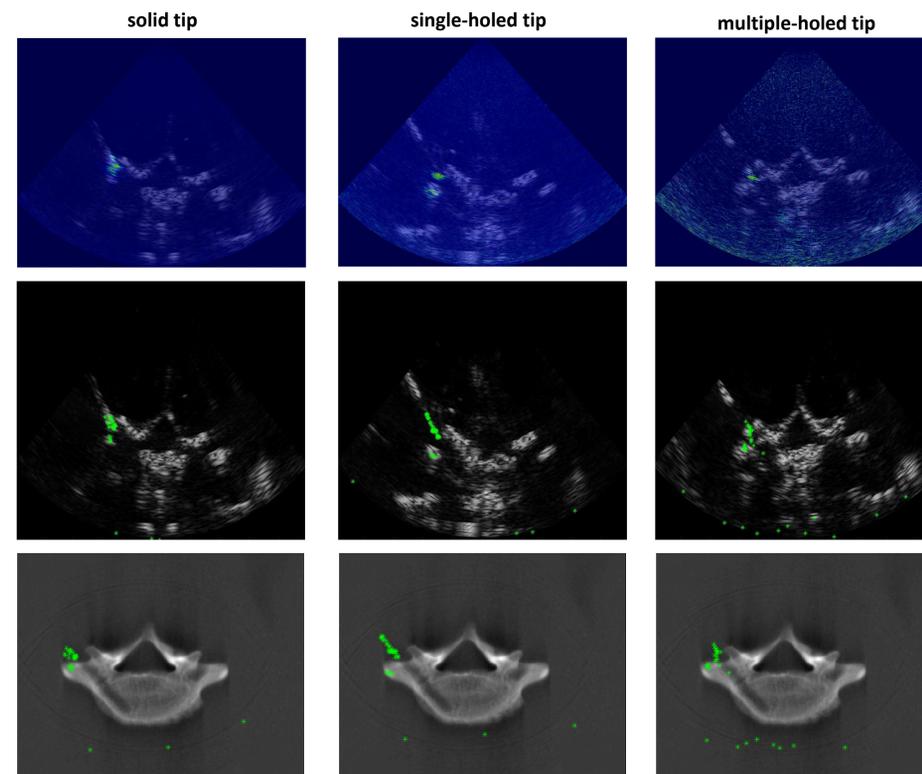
Top row: representative PA image overlaid on US image; Middle row: tracking results on US image; Bottom row: coordinates overlaid on CT registered image.
